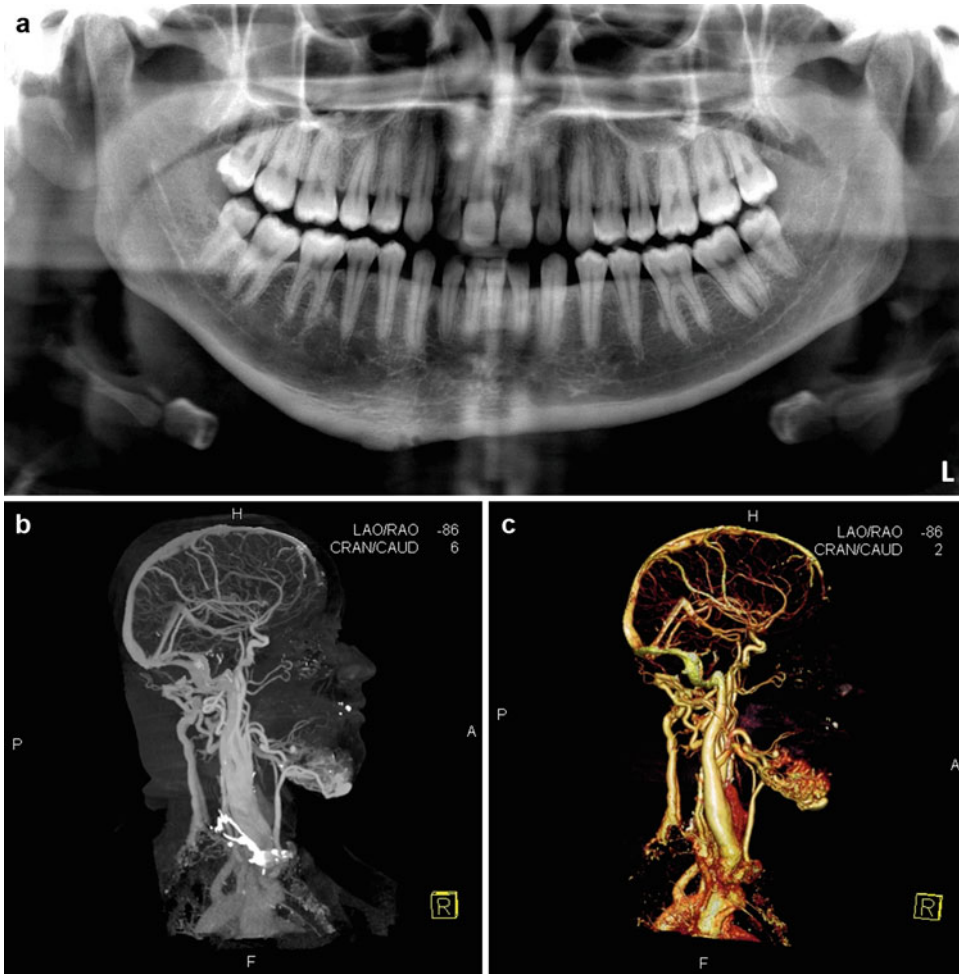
Orthopantomogram showing deformity of the anterior right mandible demonstrating asymmetry and expansion of the inferior border (a). Maximum intensity
